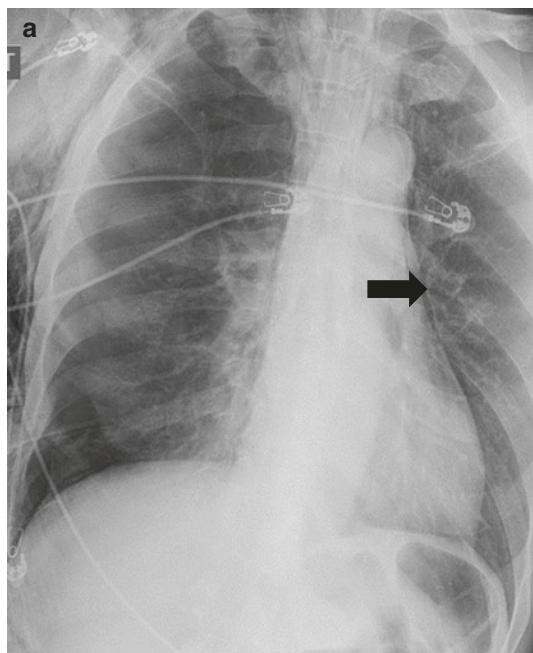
Fifty eight-year-old man presenting with chest pain after fall and blunt trauma to the chest. Chest radiograph (a) and Axial IV contrast-enhanced CT chest image
